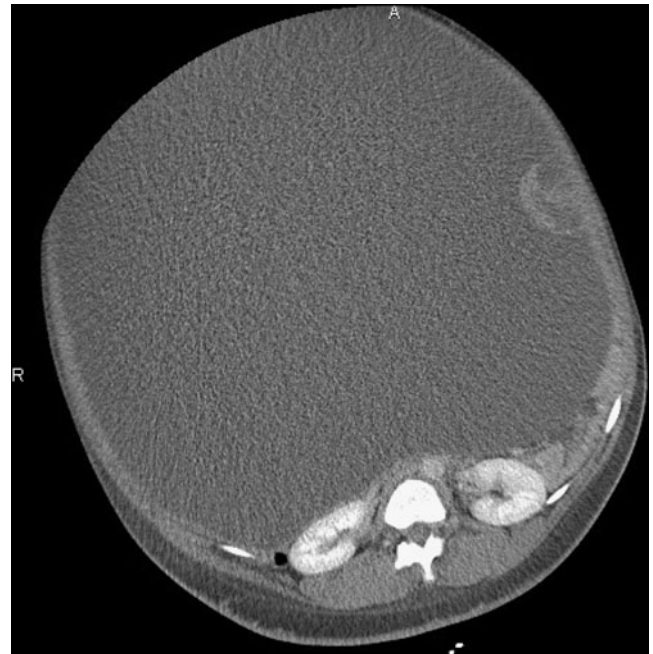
Computed tomography scan showing a large fluid density mass with a papillary projection
